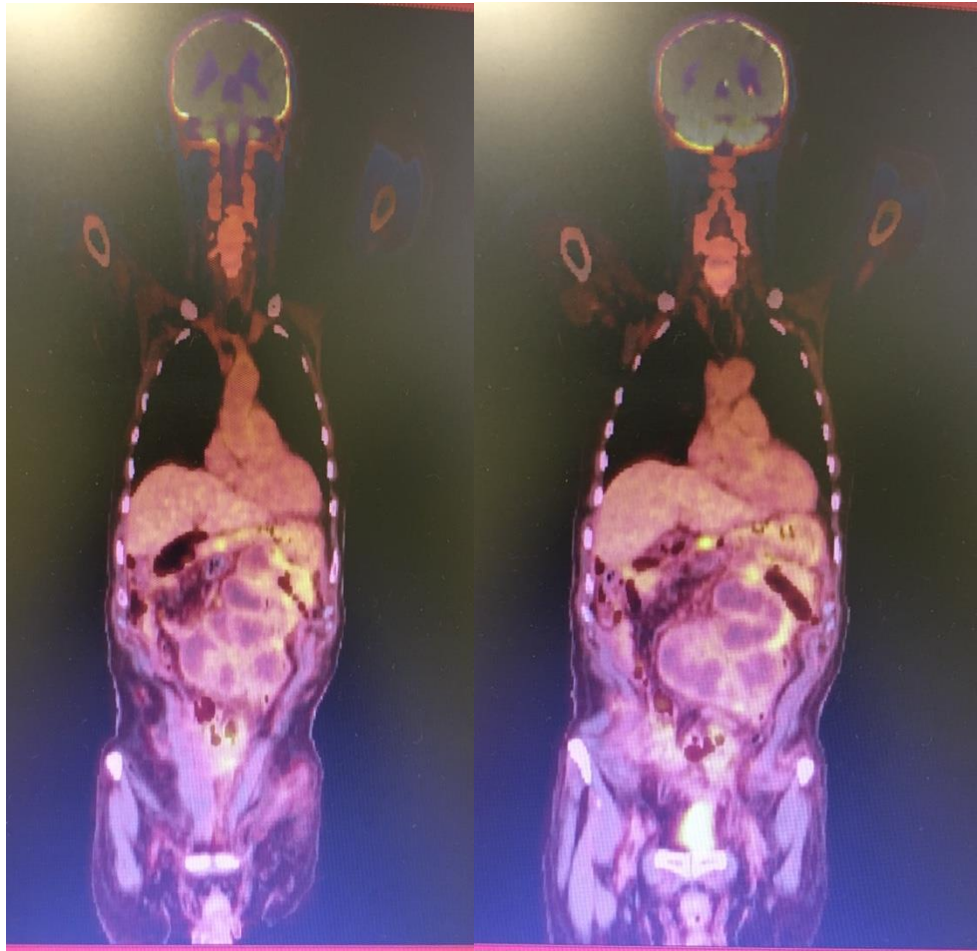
CT scan showing irregular soft tissue thickening of the upper abdominal and parietal peritoneum with ill-defined soft tissue density along the stomach bed, the inferior aspect of Left diaphragm; mid and distal portions of transverse colon also showed luminal narrowing. Markedly dilated fluid filled jejunal loops reaching a diameter of 5 cm, with mild diffuse mural thickening
